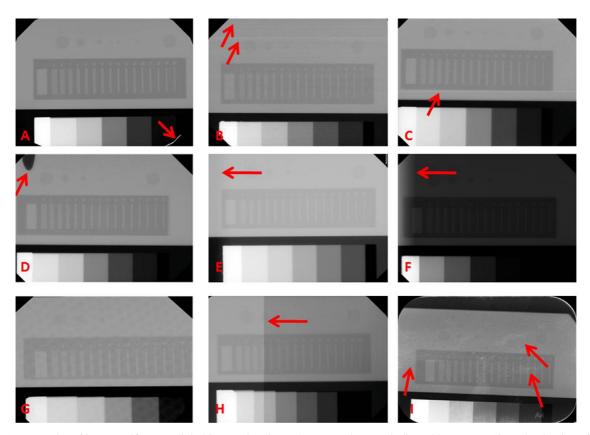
Examples of image artifacts on digital intraoral radiography system images, indicated by arrows. (A) Delamination of the scintillation layer in the bottom right corner. (B) Horizontal lines across image in the region of the contrast wells. (C) Row of dead pixels below the spatial resolution gauge. (D) Incomplete delamination in the upper left corner. (E) Diffuse darkened non-uniformity on the left side edge. (F) Banding or striation pattern on the left side of the image. (G) Swiss-cheese pattern (present throughout the image) from the fiber-optic plate due to lack of calibration file. (H) Light band on the left side of the image. (I) Craze lines from damaged protective coating on the photostimulable phosphor plate.
